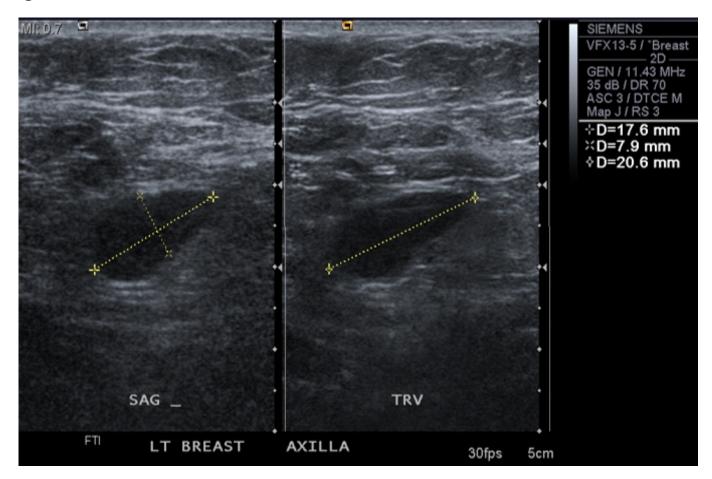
Ultrasound, Left Axilla
